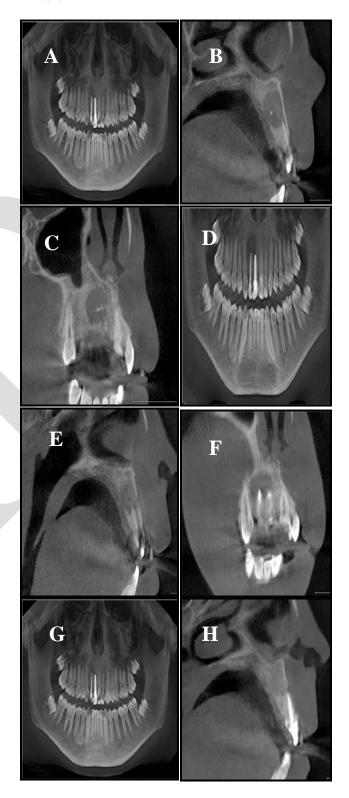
(A),(B)&(C)Preoperative panoramic, sagittal, & coronal CBCT views indicating bone pathology related to upper right central and lateral incisors, (D),(E),&(F)Immediate postoperative panoramic, sagittal,& coronal CBCT after removal of bone pathology and application of CH/nHA,(G)&(H),&(I) Six month postoperative panoramic, sagittal,& coronal CBCT showing bone formation inside the bone defect.
